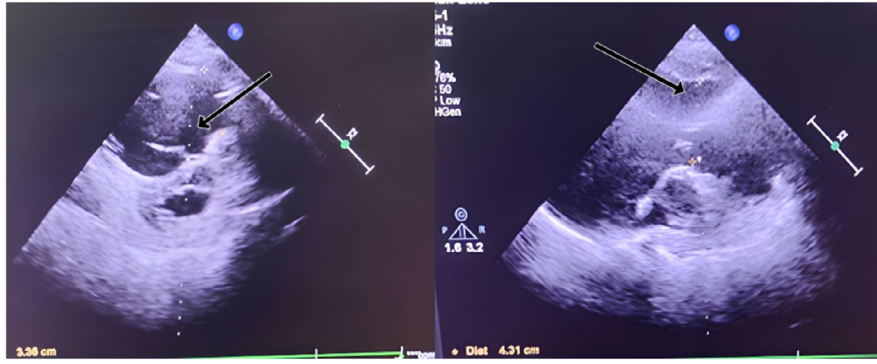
Echocardiography showing cardiomegaly with dilated right ventricular outflow tract (RVOT), pulmonary hypertension, and mild tricuspid regurgitation. Arrow showing dilated RVOT.
